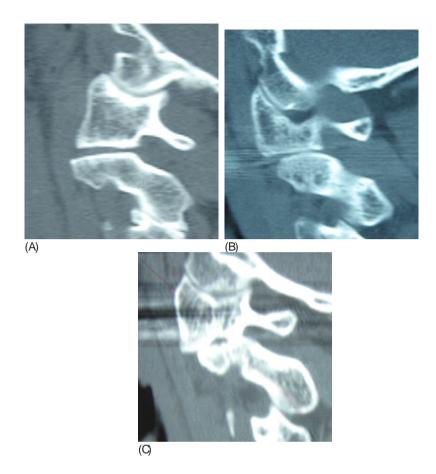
Classification of morphology of the atlanto-axial joint on CT sagittal reconstruction view before surgery. A: Grade 1, B: Grade 2, C: Grade 3
